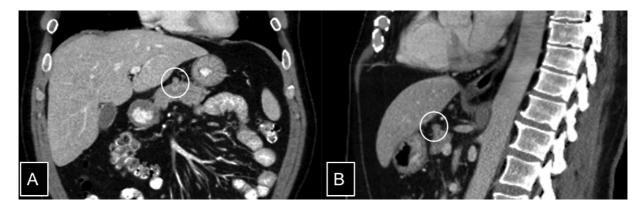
Coronal (A) and sagittal (B) views of the contrast-enhanced CT of the abdomen and pelvis demonstrate a 1.4×1.0 cm exophytic, lobulated, mildly enhancing pancreatic lesion with a tiny central hypodensity in the body of the pancreas (circled) and this corresponded to the FDG avid lesion on the PET/CT. No vascular encasement or abutment was noted.
